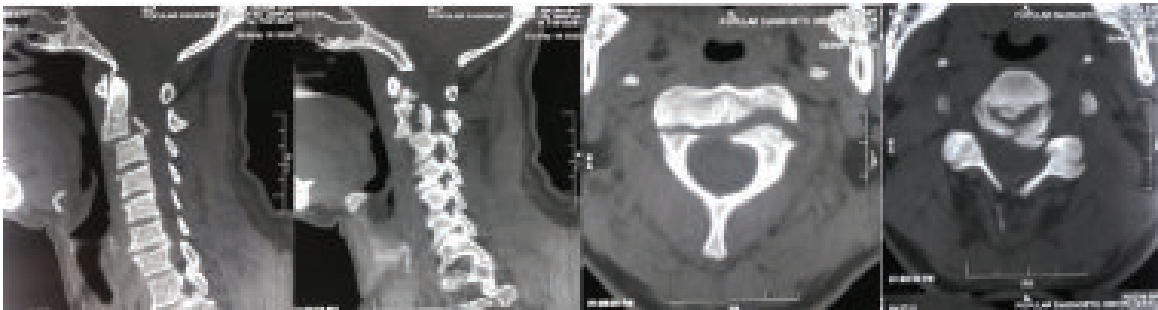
Preoperative CT scan of cervical spine
